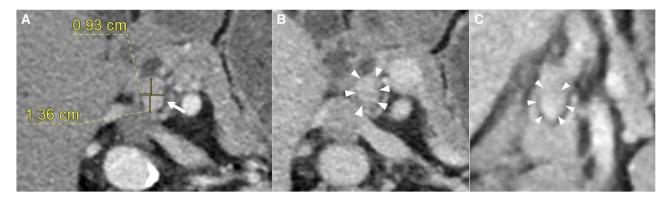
Computed tomography (CT) of the abdomen demonstrating a head-of-pancreas lesion. (A) Axial view, arterial phase. It appears to indent on the pancreatic duct (white arrow). (B) Axial view, venous phase (white arrowheads). (C) Coronal view, arterial phase (white arrowheads). The head of pancreas lesion shows arterial phase enhancement with venous phase washout, typical of pancreatic neuroendocrine tumor. No distal pancreatic ductal dilatation is seen.
